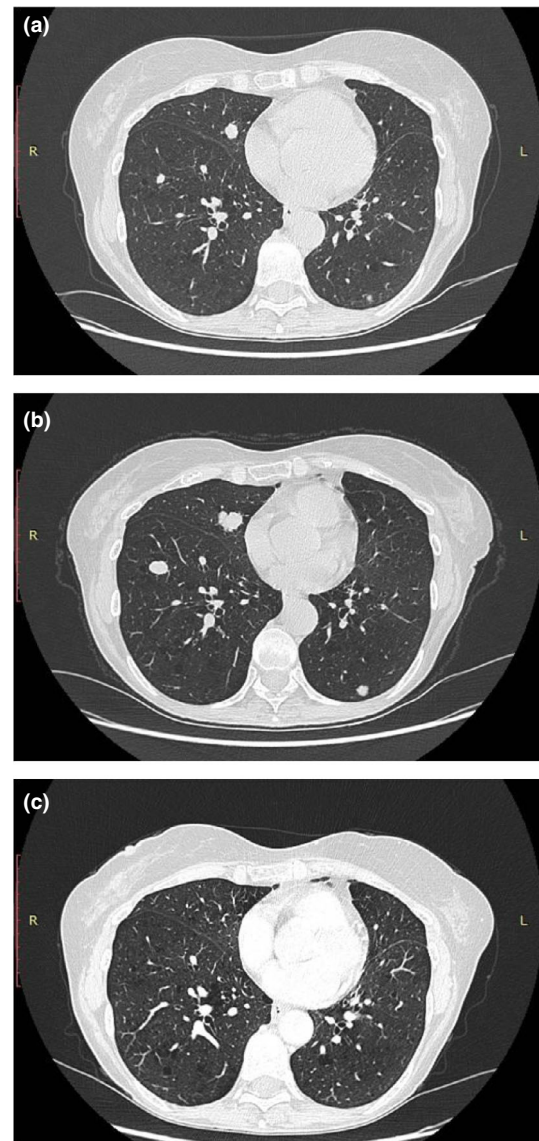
(a) Staging CT scan showing the presence of three nodular formations related to metastasis in the RLL, LLL and MLL of about 5–10 mm in diameter. (b) CT scan 4 months after metastasis appearance shows disease progression due to volumetric doubling of the three known repetitive lesions placed in the MLL, anterior segment of the RLL and posterior segment of the LLL. (c) CT scan 2 months after combo target therapy (Dabrafenib + Trametinib): complete remission of the nodular elements previously located at the pulmonary bases.
